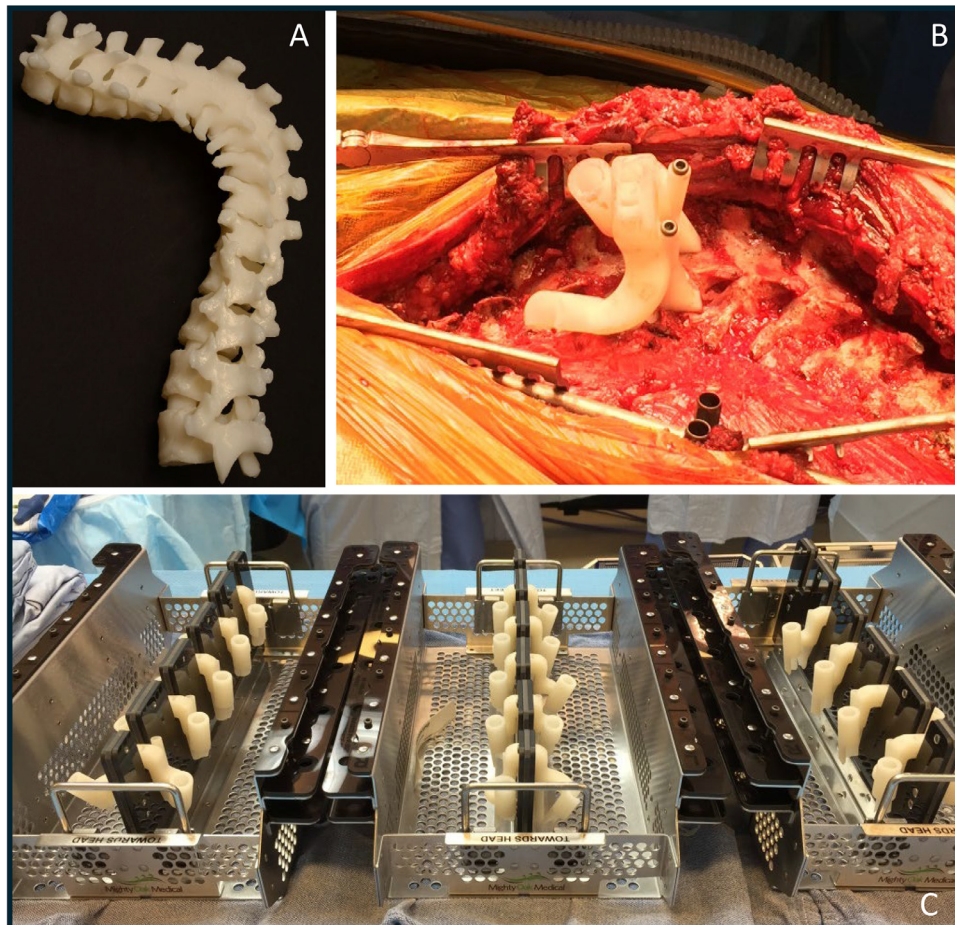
(A) A 3D model of the patient is created from a CT scan. (B) Pedicle screw guides are made to fit the model based on anatomy and can be positioned onto the spine during surgery. (C) Multiple guides are made for positioning of pedicle screws at each level based on the desired fusion construct.
